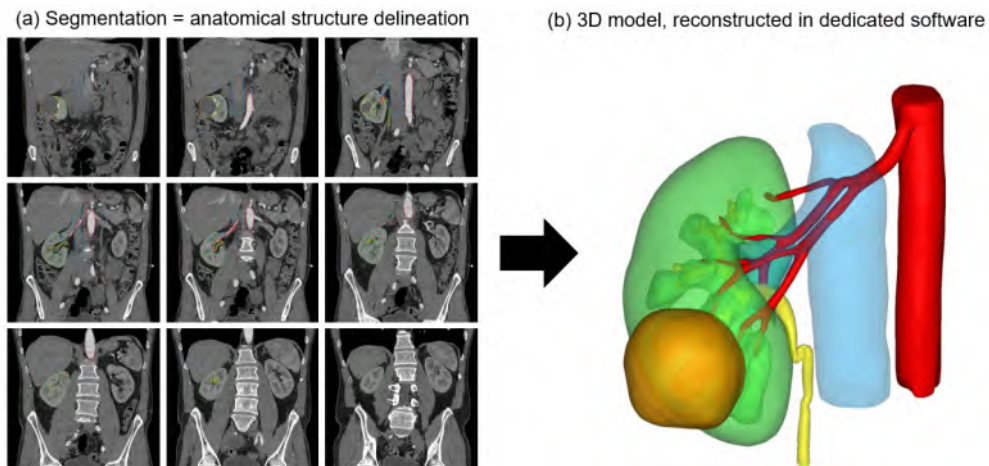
Generation of 3D segmented models by the process of segmentation (examples prepared using Mimics software (Materialise, Belgium)). (a) the operator manually or semi-automatically delineates all structures of interest in different CT slices. (b) the software package reconstructs a 3D volume from this sliced information which can be manipulated.
